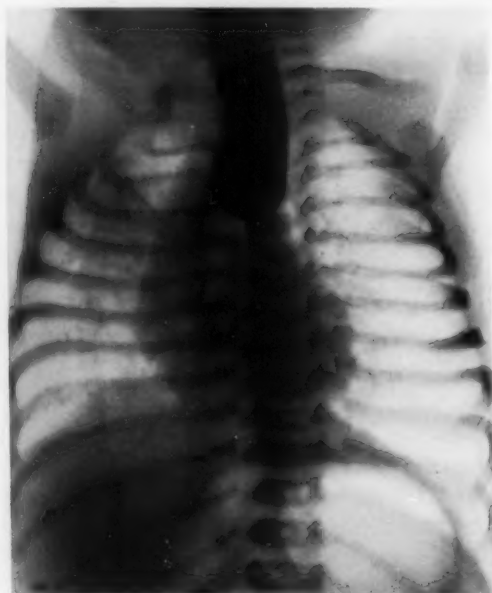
Roentgenogram of an infant, age 5 days, with congenital atresia of the esophagus. The symptoms were frequent attacks of choking with cyanosis, particularly when fluids were given. Aspiration of mouth secretions gave temporary relief. Thymic enlargement was suspected and two Roentgen treatments were given without benefit. Laryngeal stenosis was suspected, but before proceeding with direct laryngoscopy, functional study of the esophagus was recommended. The diagnosis was obvious.
